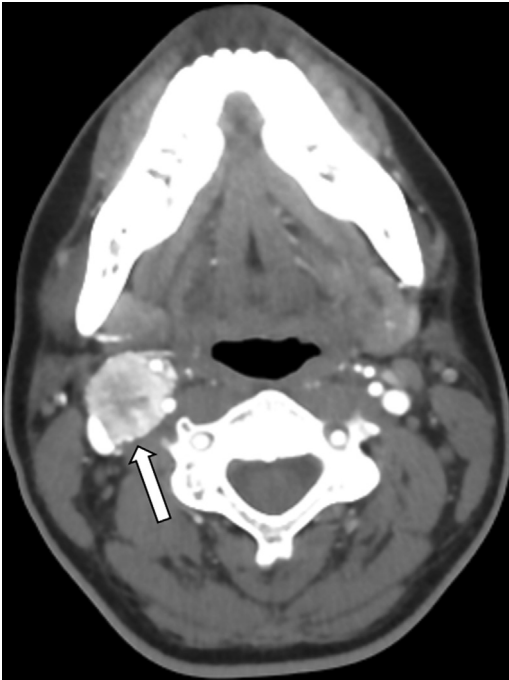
Axial contrast-enhanced CT image demonstrating an avidly enhancing mass (arrow) in the right carotid space with splaying of the internal and external carotid arteries, characteristic of a carotid body paraganglioma. The patient subsequently underwent genetic testing and was found to have hereditary paraganglioma–pheochromocytoma syndrome secondary to a *SDHB* mutation.
